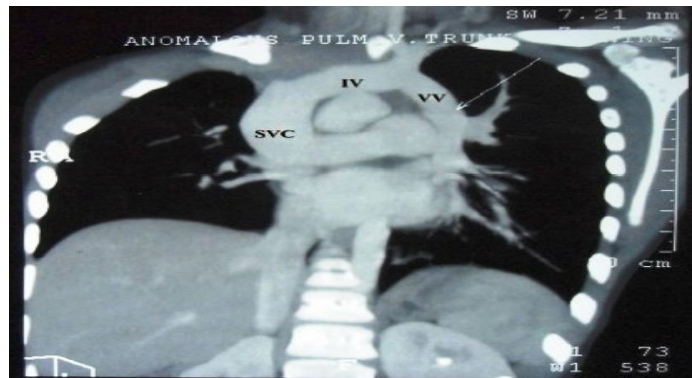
Contrast enhanced CT scan showing left pulmonary veins draining into superior vena cava via the innominate and vertical veins (SVC-superior vena cava, VV-vertical vein, IV-innominate vein)
